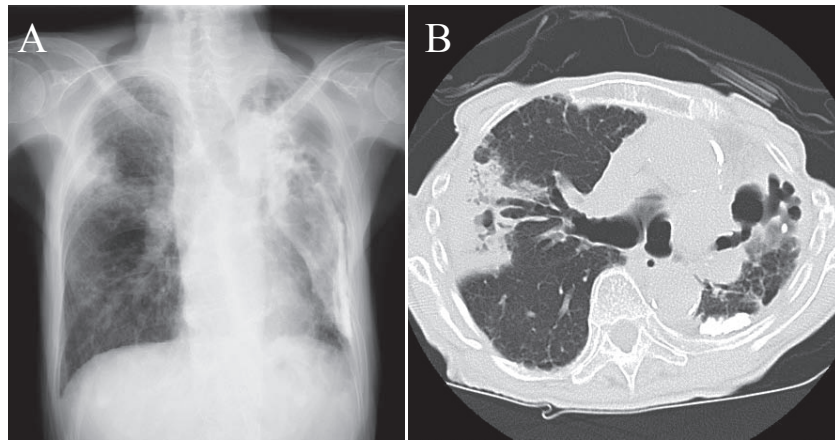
Radiographic examinations at the time of presentation. (A) Chest X-ray showed bronchiectasis and infiltration in the right middle lung field. Bronchiectasis and cavities from the left apex to the middle lung field and calcification of the left pleura, which were thought to be from old tuberculosis, were also observed. (B) Chest computed tomography showed consolidation and bronchiectasis in the right S3.
